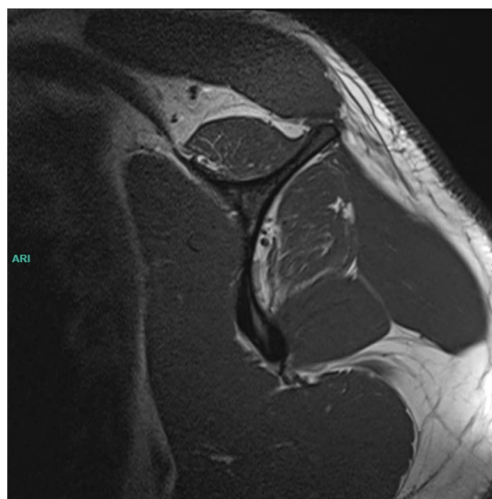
Sagittal view of MRI of left supraspinatus and infraspinatus showing atrophy with evidence of degeneration.
